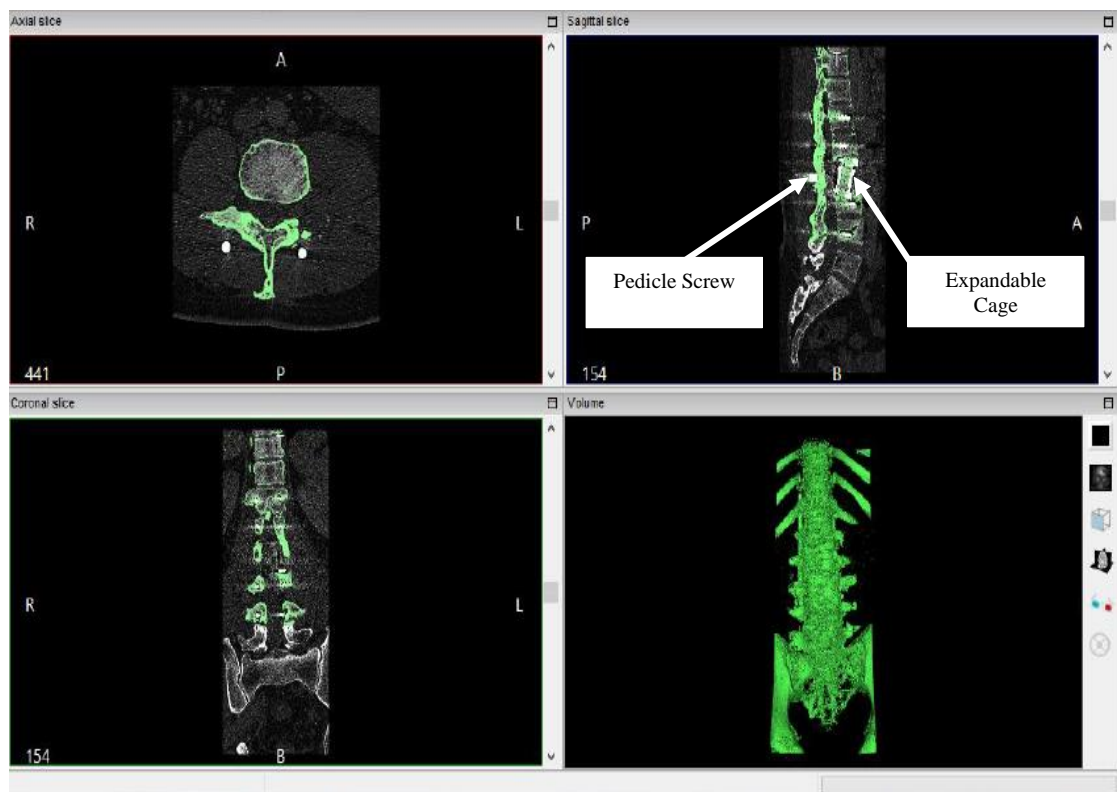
CT Scan of Pedicle Screw and Expandable Cage
